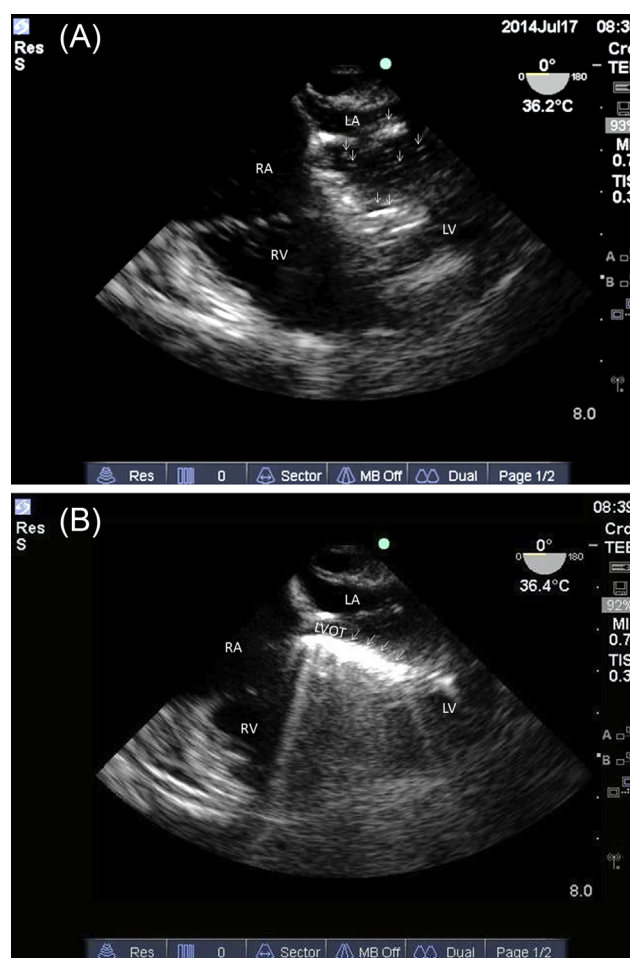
Intra-arrest transesophageal echocardiography images. (A) Midesophageal four-chamber view showing small and large reflections inside LV (arrows); (B) repeat midesophageal four-chamber view minutes later showing dense accumulation of air (arrows) along LVOT. LA = left atrium; LV = left ventricle; LVOT = left ventricular outflow tract; RA = right atrium; RV = right ventricle.
